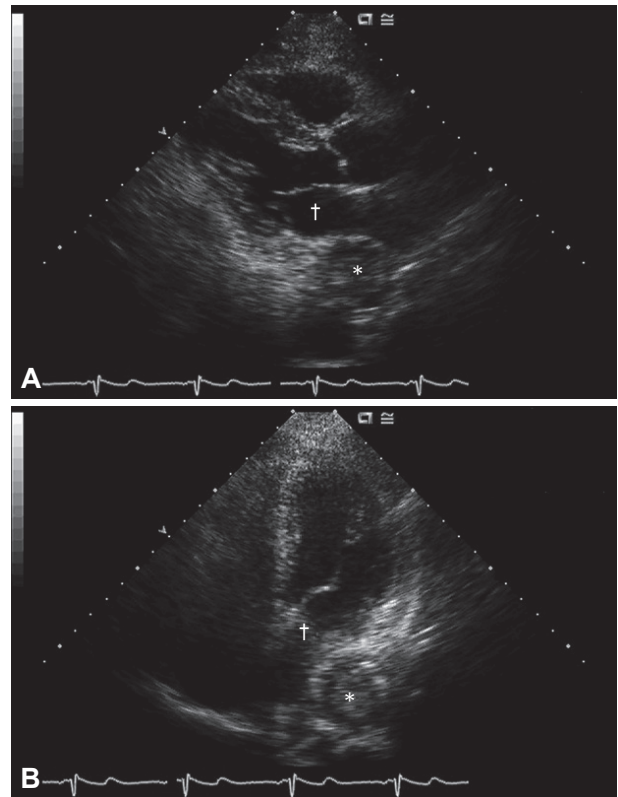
Two-dimensional echocardiographic parasternal long axis view (A) and apical four-chamber view (B). A round and well-demarcated esophageal mass (*) compresses the left atrium (†), which resembles the image on chest CT.
